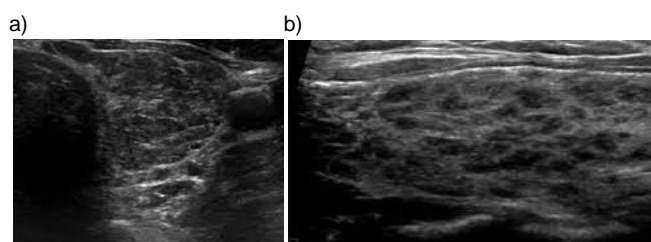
An ultrasonographic cross-sectional and longitudinal image of the thyroid gland presenting a nonhomogeneous thyroid gland with hypoechoic structure and pseudonodules
